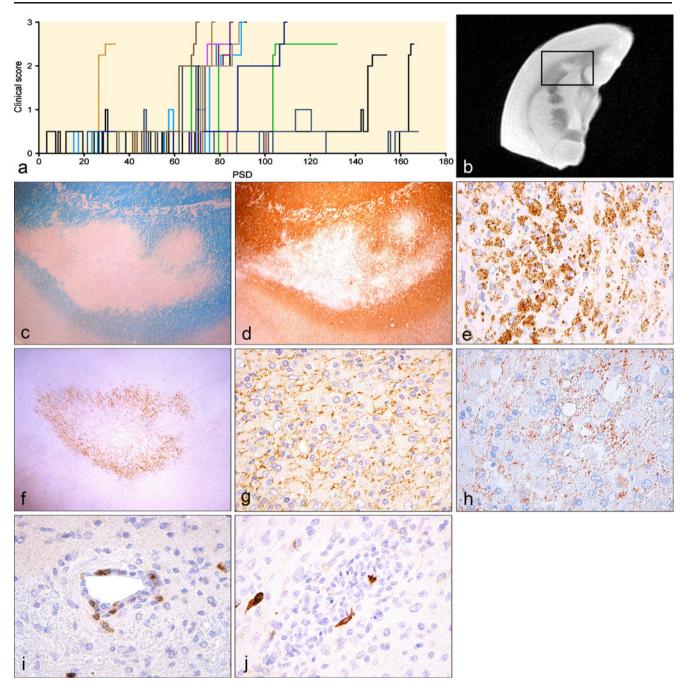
Clinical and pathological hallmarks of MOG_{34-56} /complete Freund's adjuvant (CFA) model in marmosets. Clinical scores of 16 marmosets immunized with MOG_{34-56} in CFA are shown (a). Clinical scoring system described in 't Hart et al. (2008). T2-weighted magnetic resonance imaging of a 4% buffered formalin-fixed brain of one of the marmosets shows a characteristic hyperintense brain lesion (b). The pathology of the lesion in the *rectangle* is further characterized (c-j).
